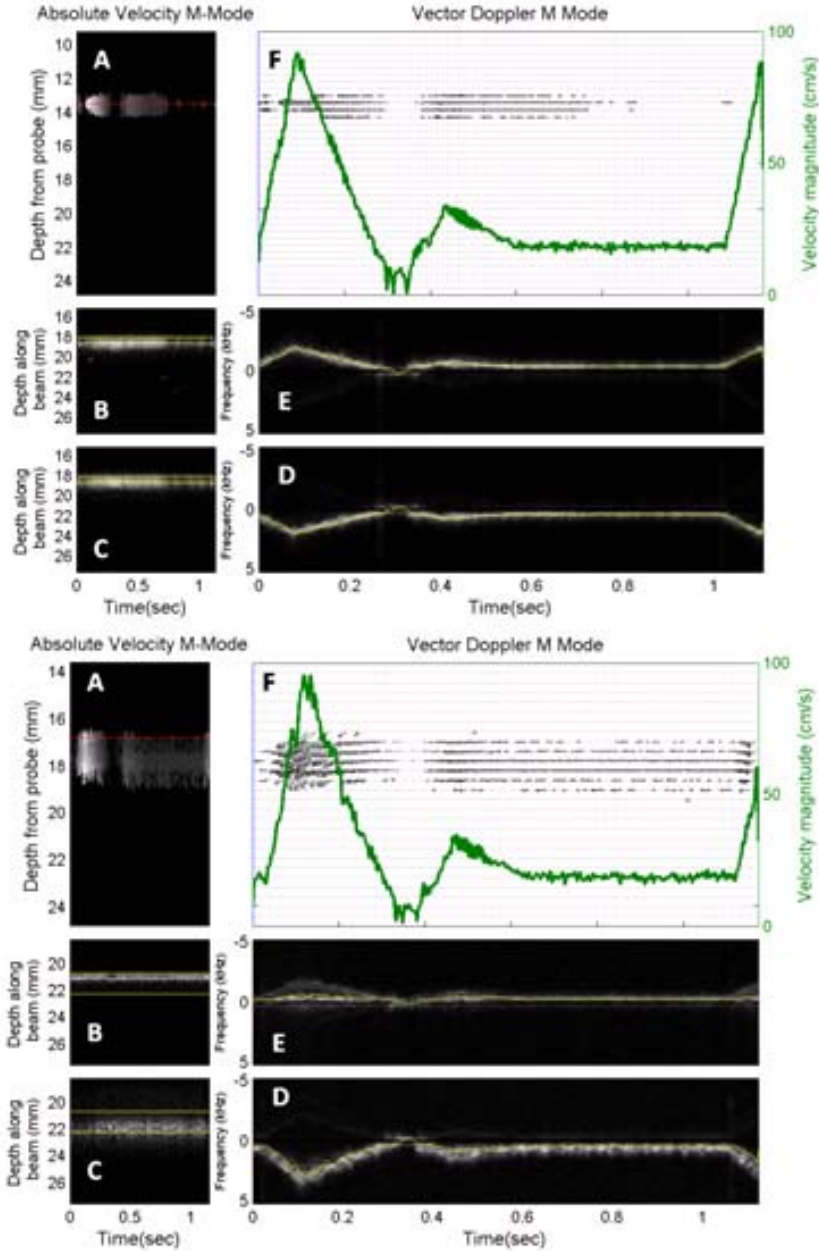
Vector Doppler displays for $\beta = 45$ and $\theta = 90$ (top panel) and $\beta = 45$ and $\theta = 75$ (bottom panel). (a) The velocity magnitude displayed as an M-mode with depth from the transducer on the vertical axis and time on the horizontal axis. (b), (c) Echo M-mode with depth along the steered receive beam for receive apertures 1 and 2, respectively. (d), (e) The spectrogram of the received echoes from the region of interest for each receive apertures 1 and 2, respectively. (f) Velocity M-mode with arrows representing the flow vector.
